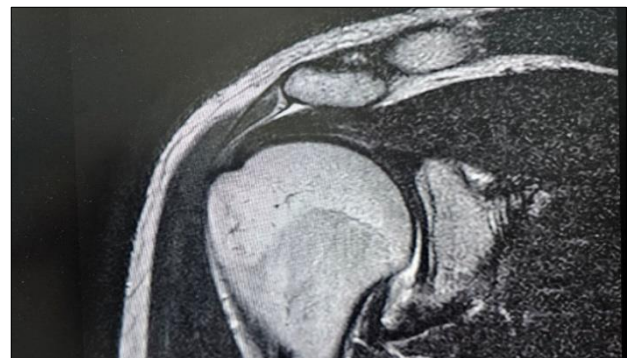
MRI image showing significant improvement and healing of tendonitis 6 months after PRP injection
